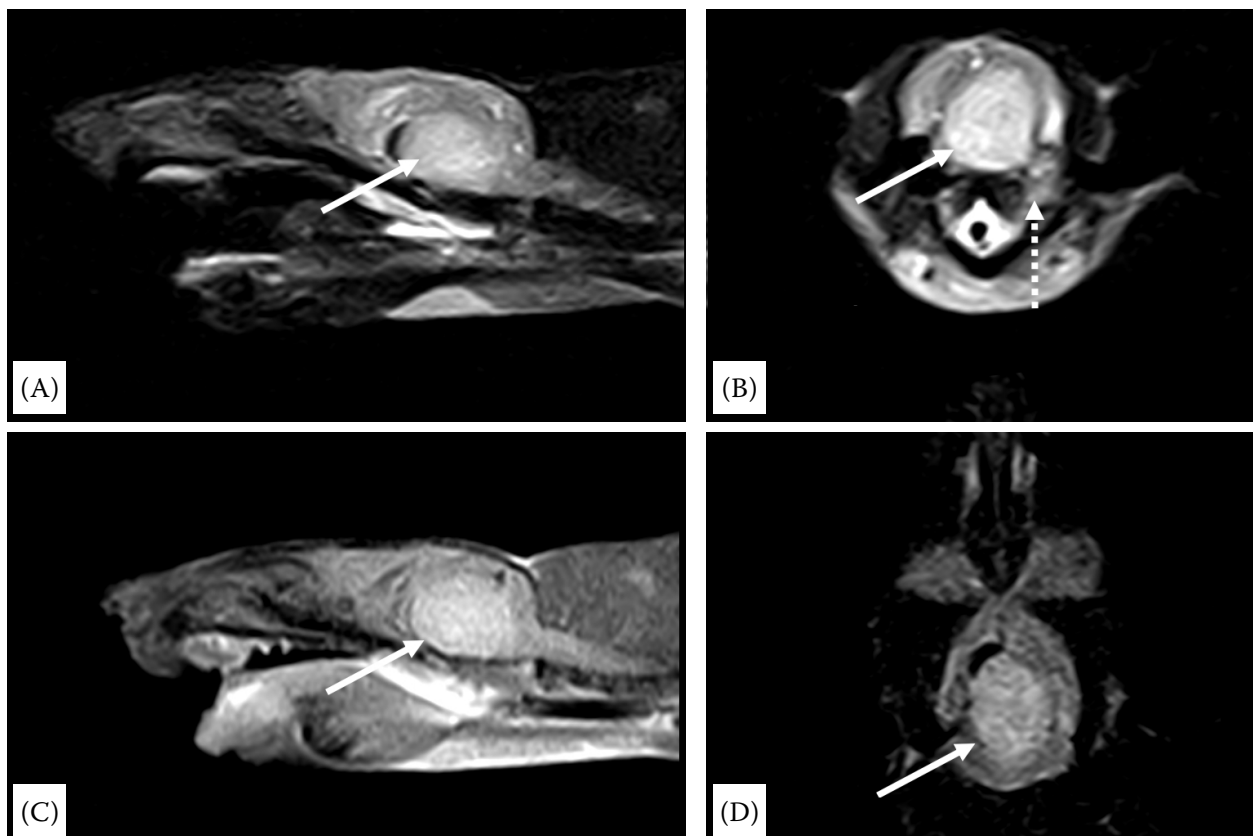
FSE T2w sagittal (A) and transverse (B) images of the brain mass characterised by a hyperintense and heterogeneous aspect (solid white arrow). SE T1w Sagittal (C) and FLAIR dorsal images (D) of the brain mass; notice the hyperintense aspect in both the sequences (solid white arrow)
